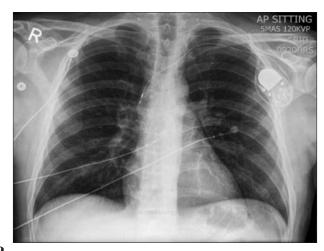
Chest radiograph showing the tip of the pacemaker out of position in the proximal superior vena cava. The pacing generator had rotated about 180 degrees counterclockwise, and the lead was pulled around it.
